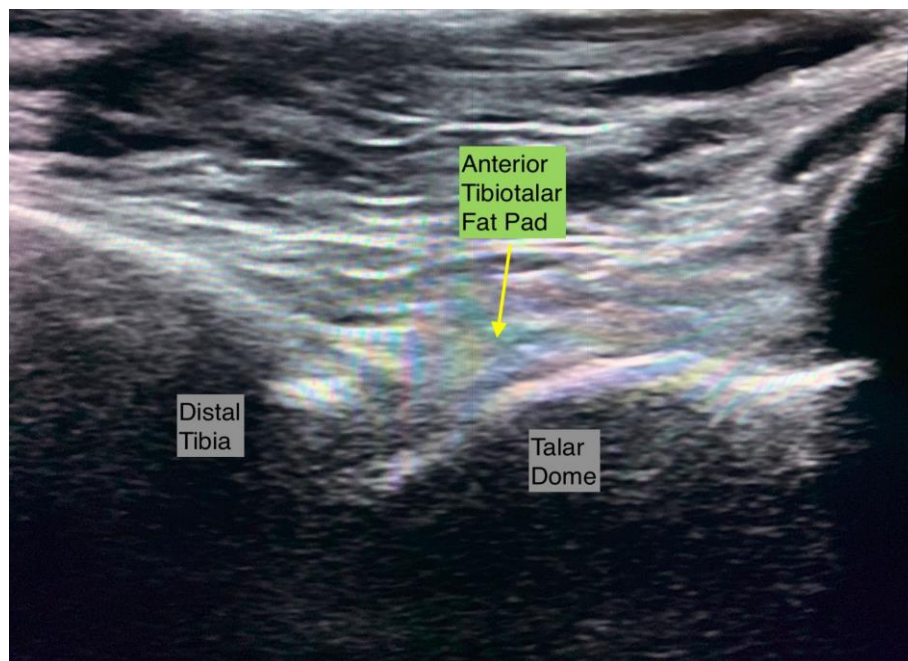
Long axis ultrasound view of the normal unaffected ankle joint
